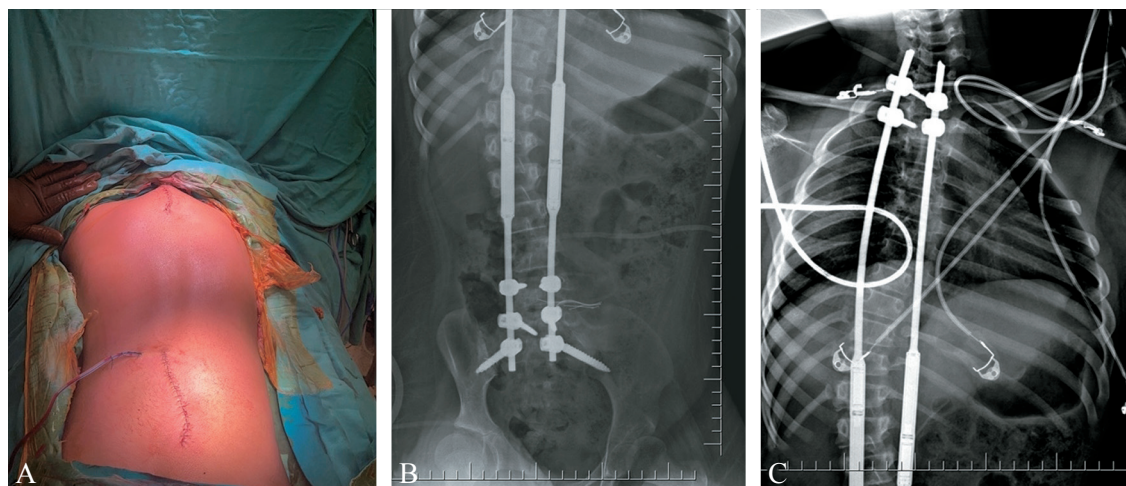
Surgical field and X-ray images of rods: A) surgical incisions and drain; B) posterolateral X-ray image of instrumentation; C) anterior X-ray image of instrumentation.
